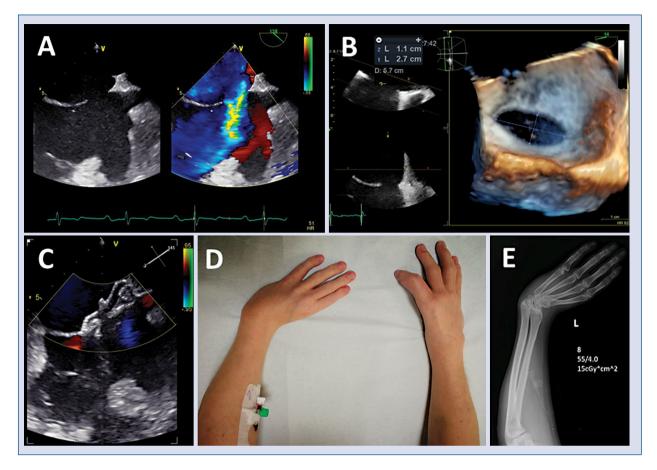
A. Two-dimensional transesophageal echocardiography with color Doppler — type II atrial septal defect with hemodynamically significant left-to-right shunt; B. Three-dimensional transesophageal echocardiography — elongated (elliptic, 27×13 mm in size) type II atrial septal defect; C. Two-dimensional transesophageal echocardiography with color Doppler — good result of Memopart 26 mm occluder implantation; D, E. Malformation of upper limbs (real photo and X-ray) — absence of I metacarpals and thumbs.
